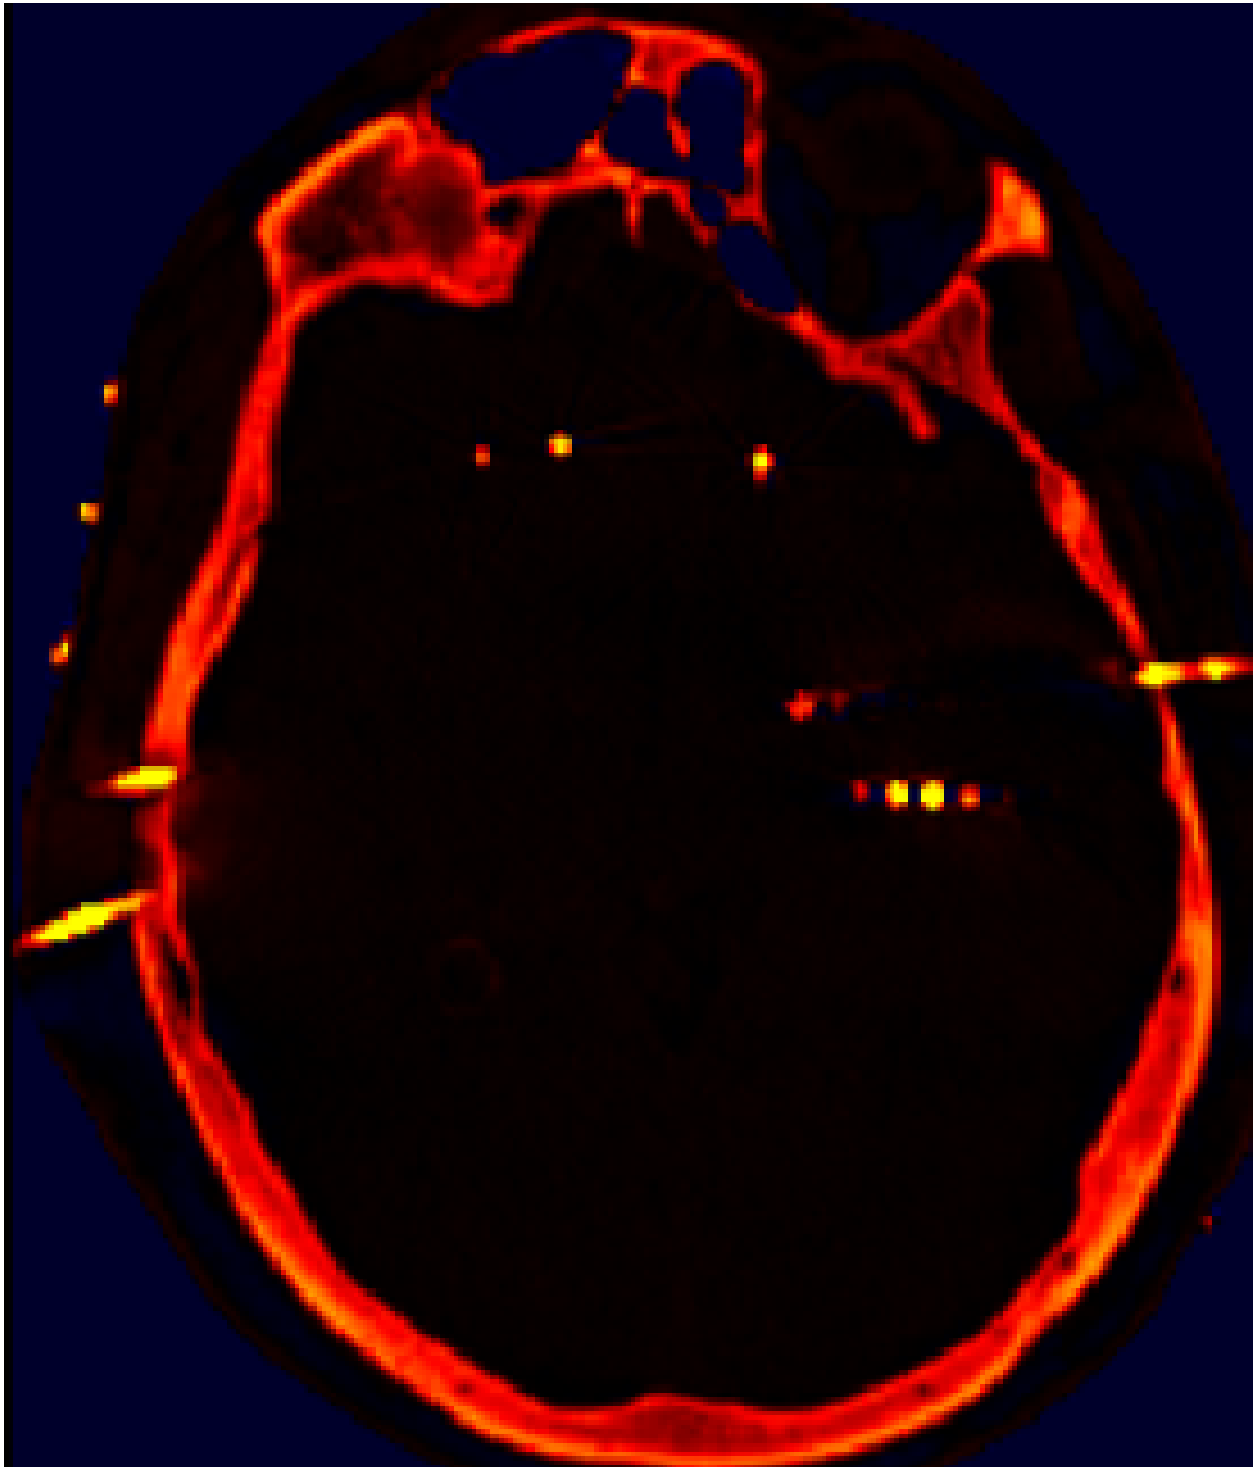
A post-operative CT scan overlaid with a heat colormap. The bright red dots represent the contact points lying on a particular axial slice
